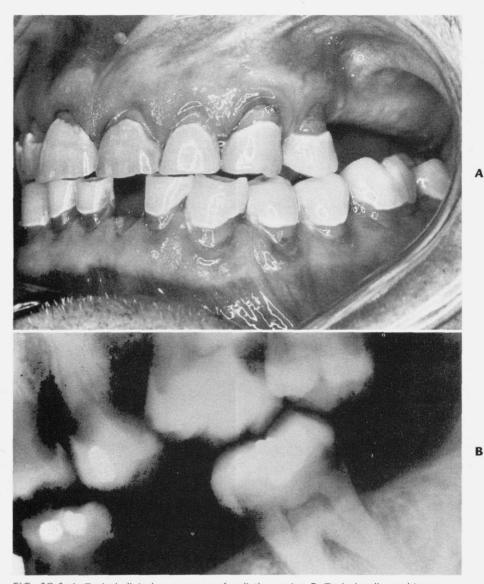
A, Typical clinical appearance of radiation caries. B, Typical radiographic appearance of radiation caries. Note the erosion around the cervical portion of the teeth.
